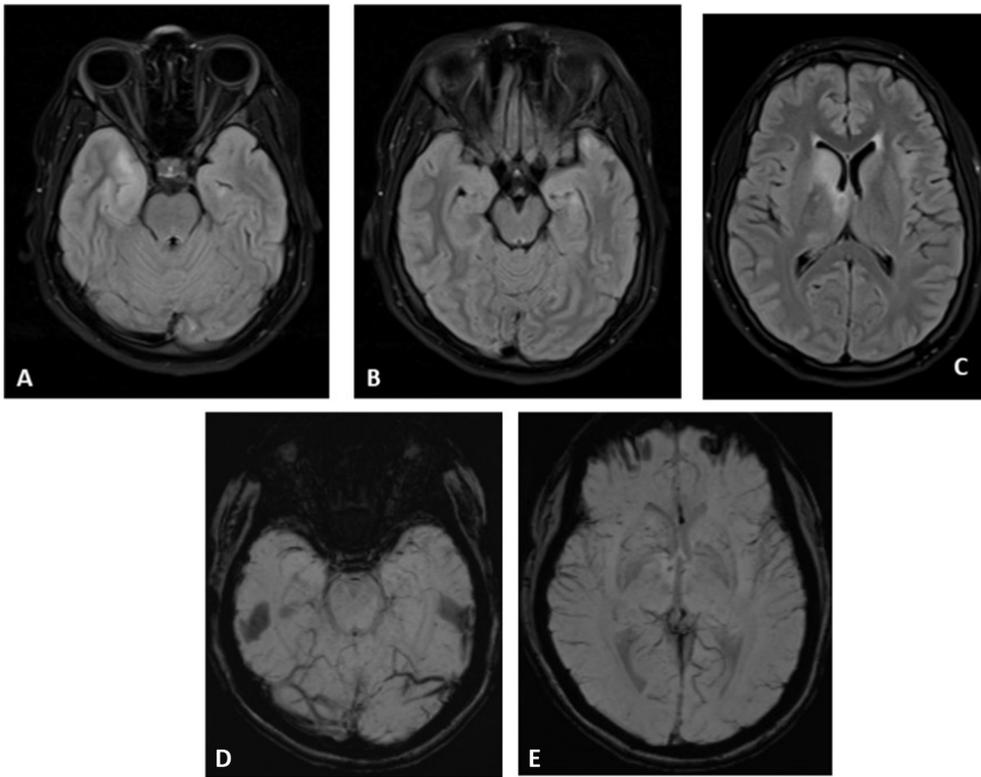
1A–1C: FLAIR axial: Bilateral optic nerves show normal signal intensity but altered increased signal is noted in right medial temporal region (A), adjacent to the left temporal horn and the left temporal tip (B), the right caudate, right medial thalamus and the left insular region (C). 1D-1E SWI axial image at the level of the midbrain does not show any abnormality (D) but the image at the ventricular level (E) shows a focal hypointensity in the right medial thalamus; subtle hemorrhagic foci are also noted in the right caudate.
